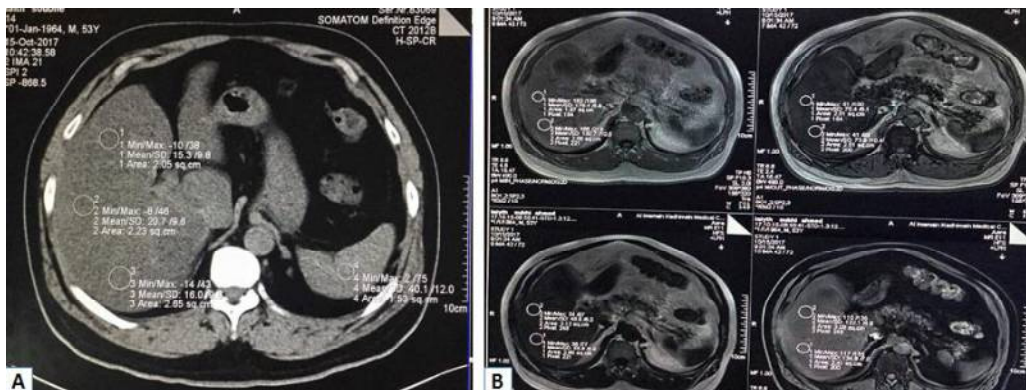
53 years old male, diabetic, elevated liver enzymes (ALT 72U/L, AST 54U/L), shows fatty liver (hepatic attenuation is 18HU, spleen attenuation is 40HU). B: MRI Dixon show liver FF of 25%.
